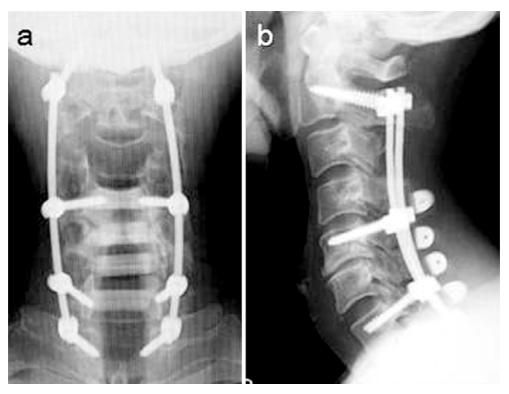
C5 pedicle screws as mid-cervical anchor in cervical laminoplasty and instrumented fusion. a Anteroposterior radiograph of cervical spine. b Lateral radiograph of cervical spine.
